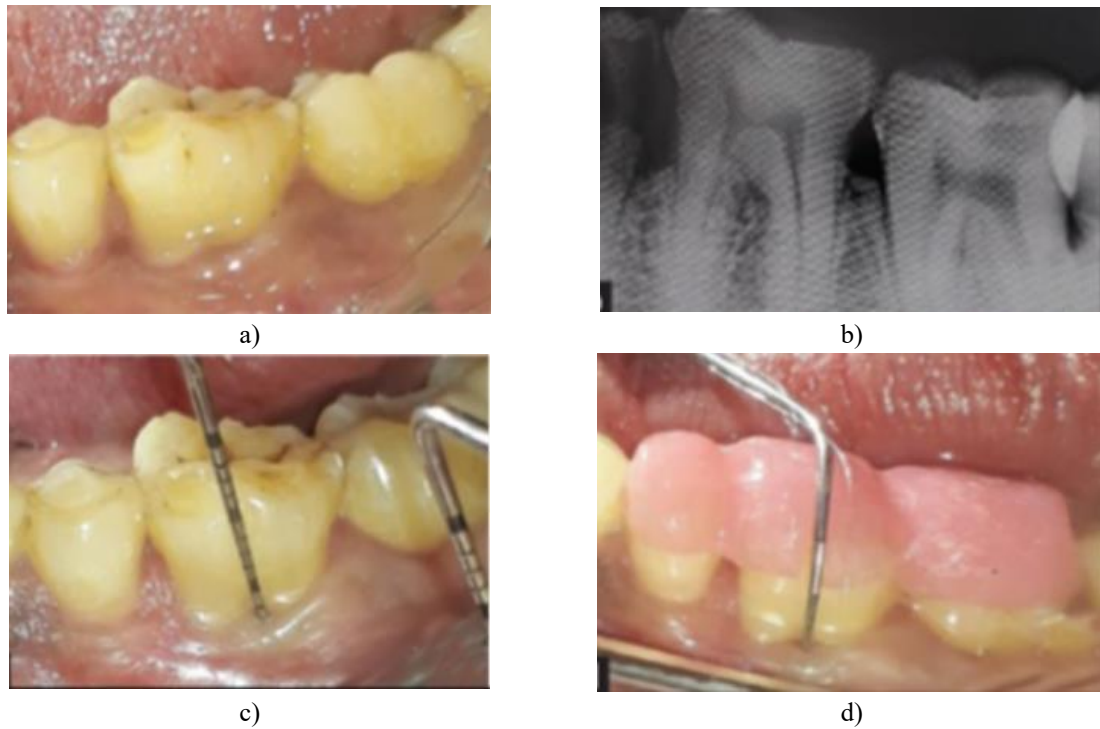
(a) Pre-operative image of test site, (b) Pre-operative intraoral periapical radiograph of the tooth with grade II furcation, (c) Presurgical measurements of vertical probing depth, (d) Presurgical measurements of horizontal probing depth
